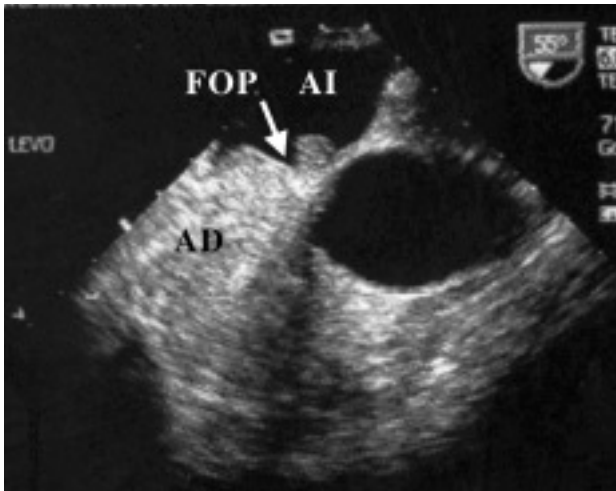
Transesophageal image showing extensive passage of contrast (agitated Hemoce®) through patent foramen ovale from the right atrium to the left atrium. RA, right atrium; LA, left atrium.
